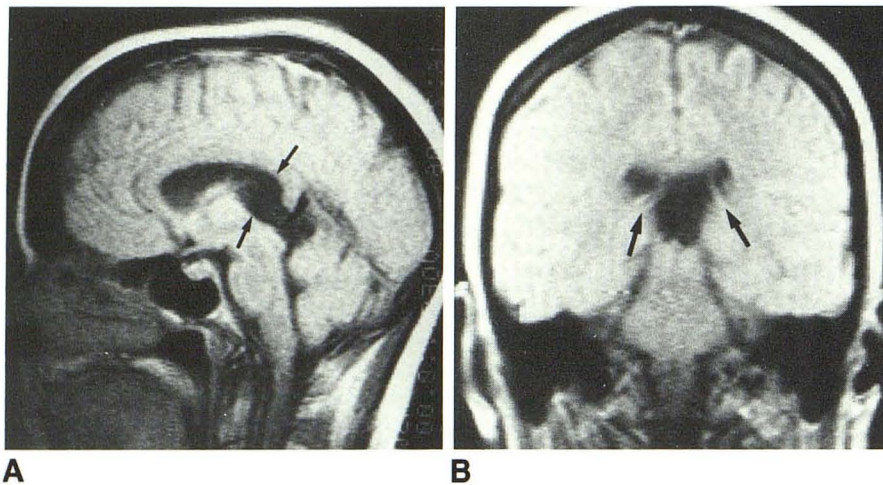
A, Sagittal T1-weighted MR image shows cyst in velum interpositum (arrows) and extending posteriorly.
